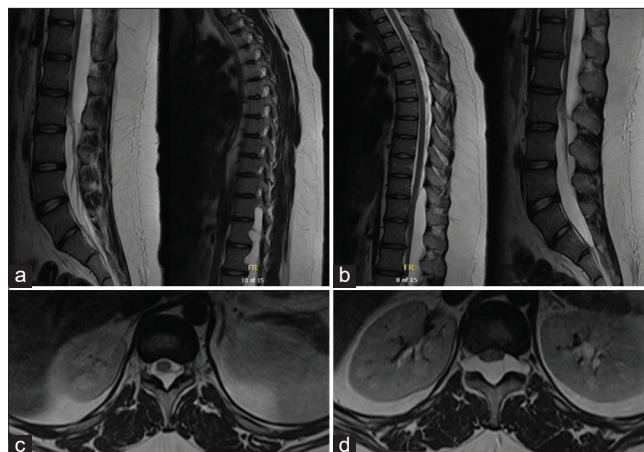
(a) Preoperative T2-weighted parasagittal thoracic and lumbar magnetic resonance imaging (MRI). (b) Preoperative T2-weighted midsagittal thoracic and lumbar MRI. (c) Preoperative T2-weighted axial MRI T11–T12. (d) Preoperative T2-weighted axial MRI L1.
